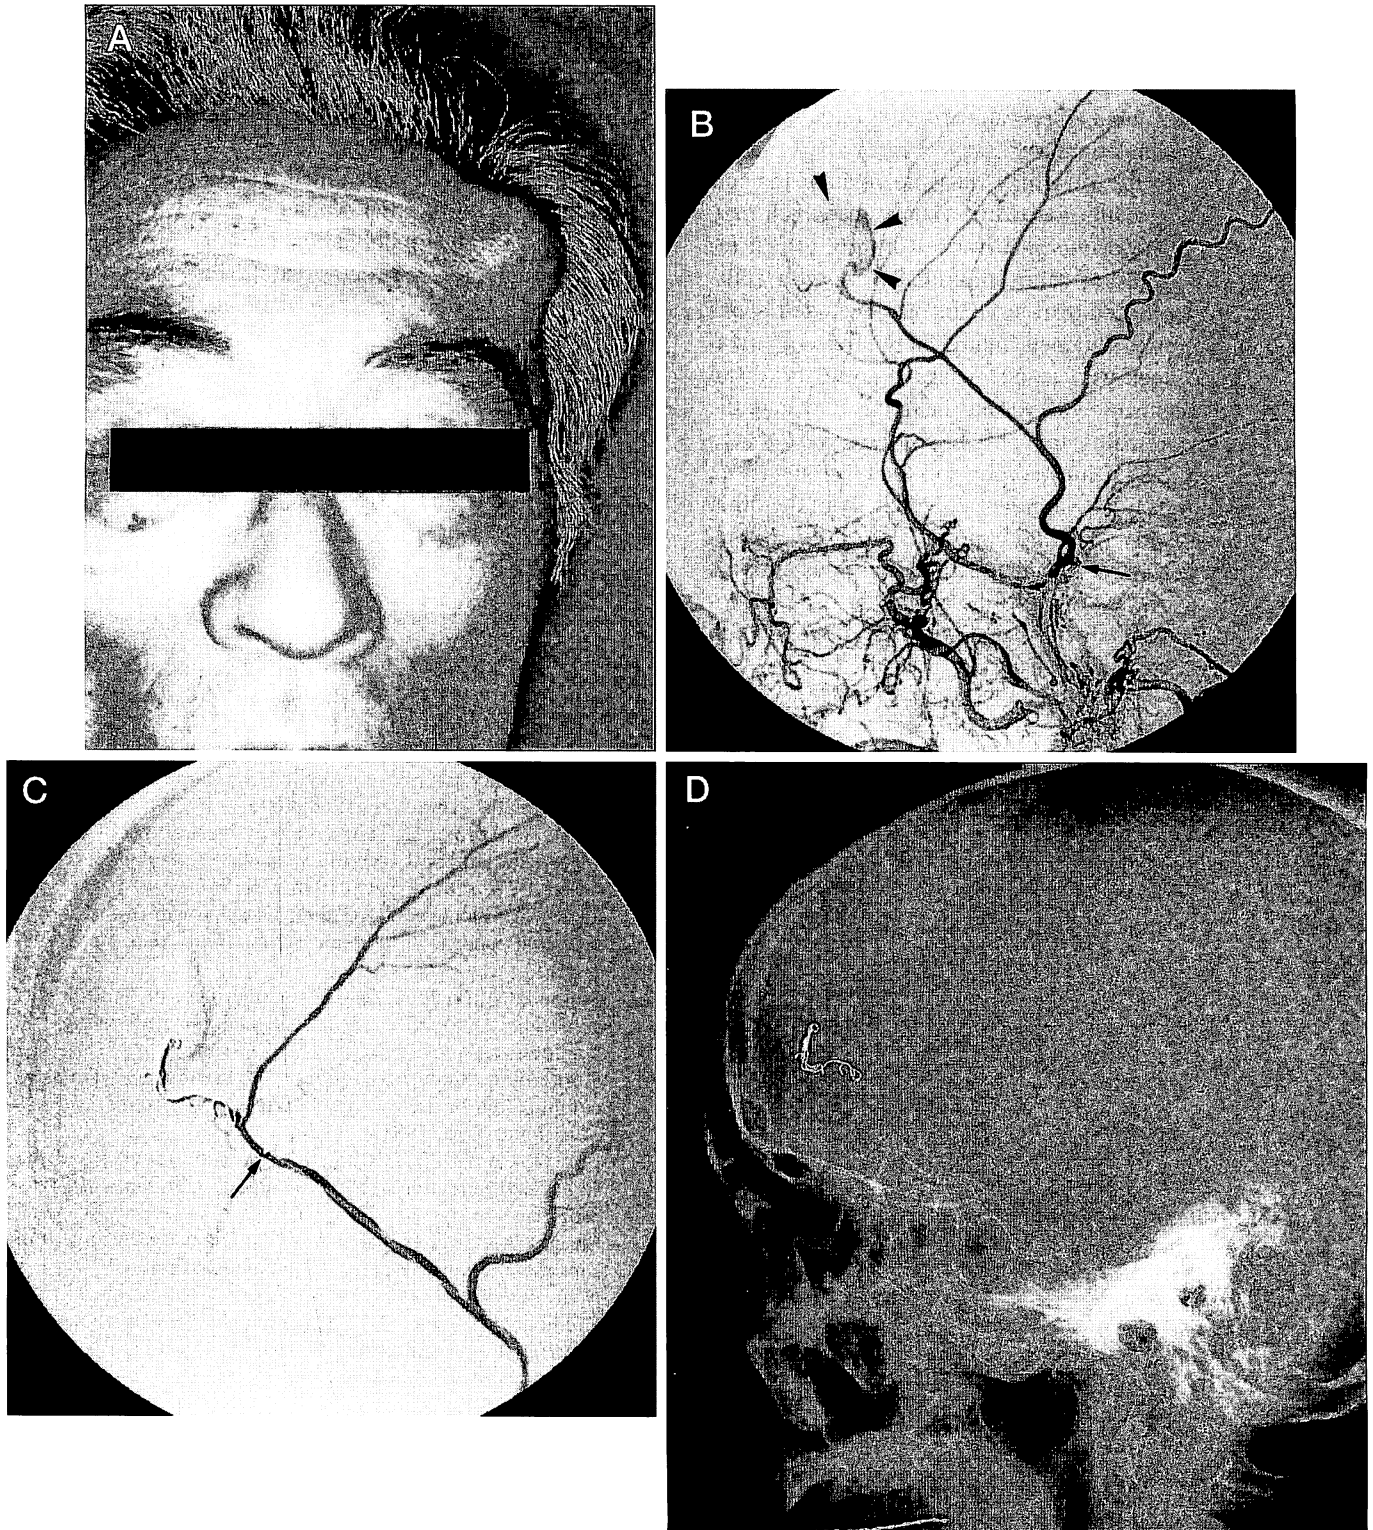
Patient 2. (A) Photograph of the left forehead pulsatile mass, 3 cm in diameter. (B) Left external carotid injection (lateral view) shows the aneurysm at the anterior branch of the STA (arrowheads). Arrow indicates coiling of the STA. (C) Immediately after coil trapping of the aneurysm, the aneurysm is no longer visible. Arrow indicates the tip of the microcatheter in the STA. (D) Plain roentgenogram (lateral view) shows the fibered platinum coils in the STA.
